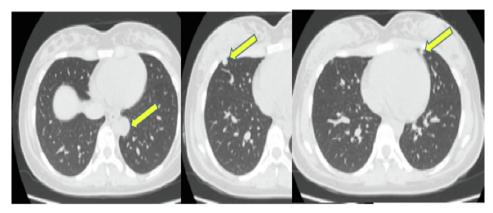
Chest computed tomography showing multiple lung nodules.
